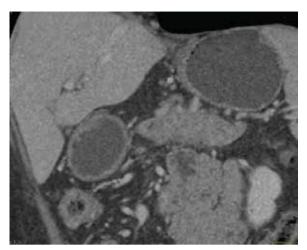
CT Abdomen (Coronal View). Pre-treatment image highlighting the "halo sign"
